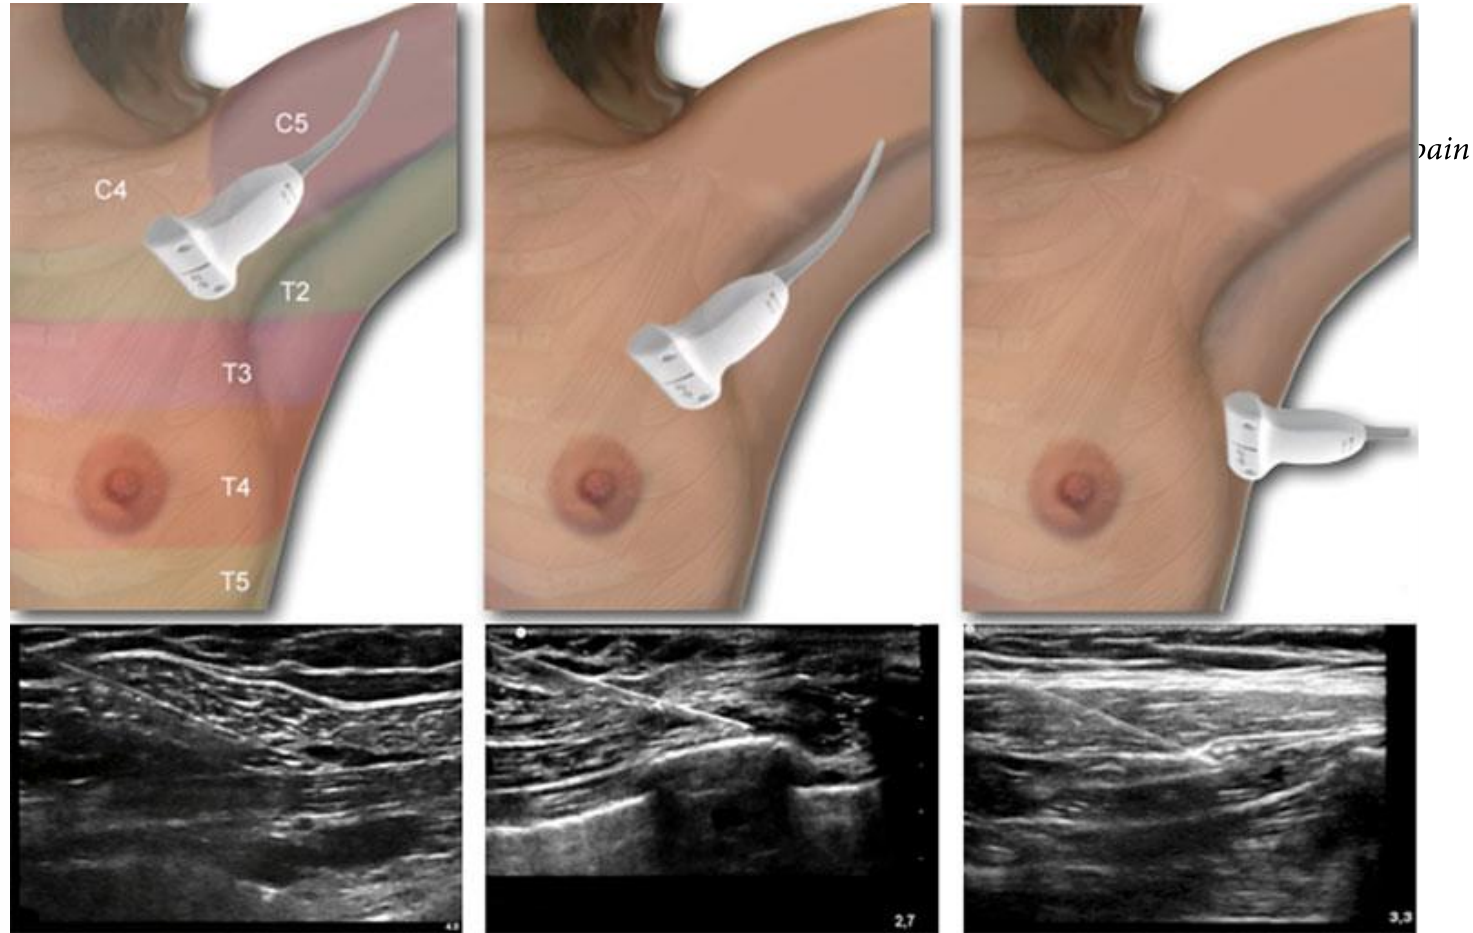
Graphic representing probe position and ultrasound image obtained during a Pecs I block (left), Pecs II block (middle) or a serratus plane block (right).
